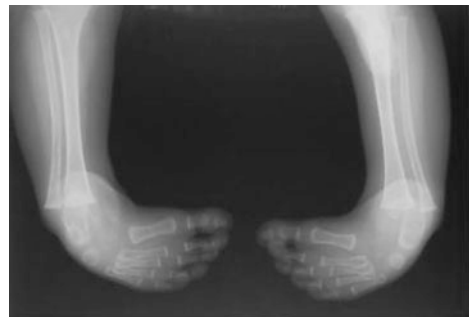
Radiograph of talipes equinovarus in another infant
